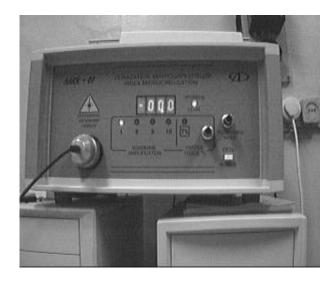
Laser-Doppler Flowmeter "LAKK-01"
